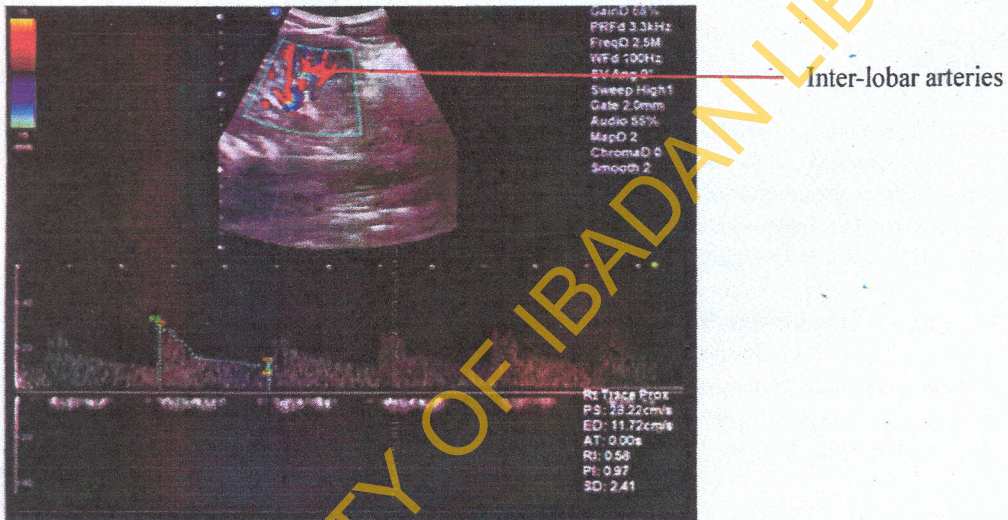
Doppler ultrasound of the kidney showing normal resistive index from the interlobar artery of a healthy kidney taken at the mid kidney
